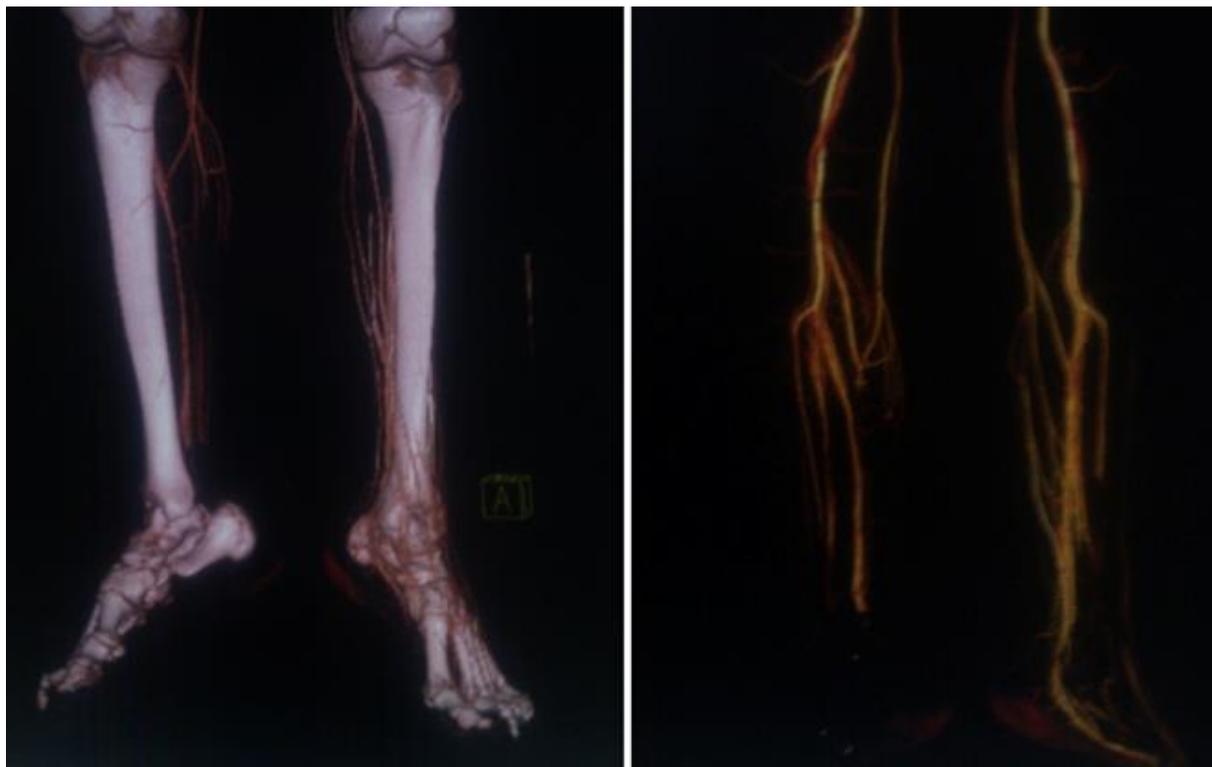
An angio-computed tomography with reconstruction of the legs showing the three Vascular axes injuries without bone involvement.
